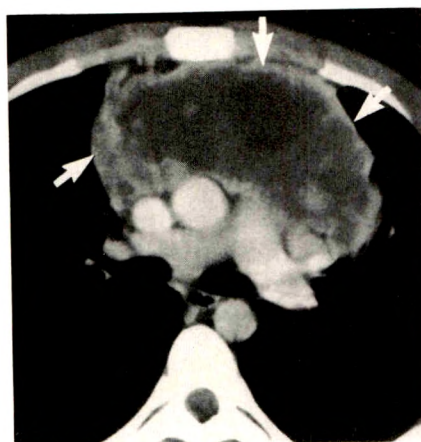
21-year-old man with non-Hodgkin lymphoma involving anterior mediastinum. Initial CT scan shows predominantly cystic/necrotic character of mass (arrows).
